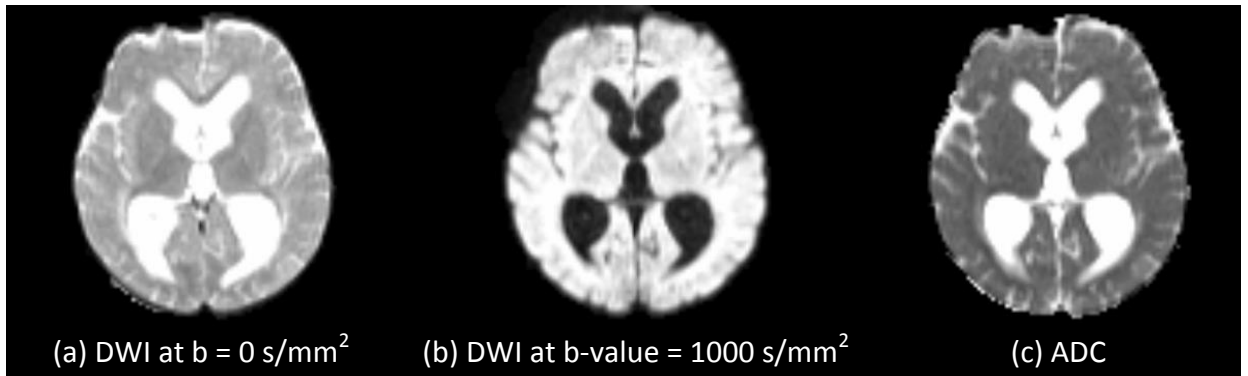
Signal intensity of restricted and unrestricted space based on DWI and ADC. An unrestricted area like CSF is bright on DWI at $b = 0$ s/mm² and an ADC map, but dark on DWI at $b\text{-value} = 1000$ s/mm² (case EP904). It is vice versa for a restricted area.
